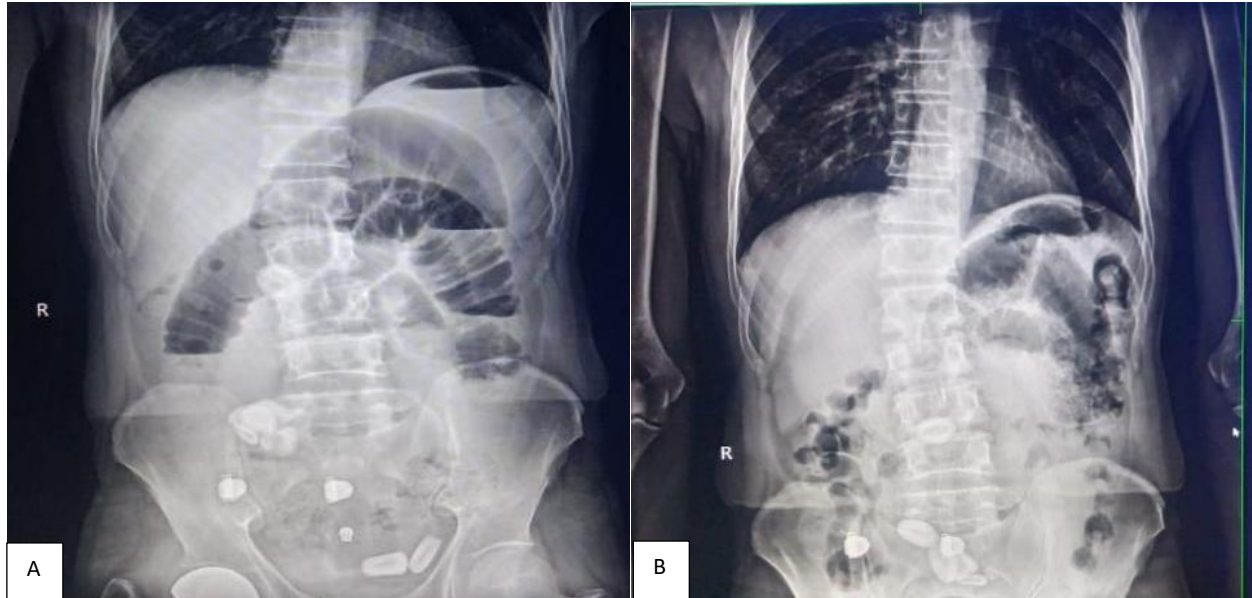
(A and B): X-ray abdomen erect showing radio-opaque densities in right iliac fossa and pelvis. Follow up x-ray abdomen erect with change of position of the radio-opaque densities.
